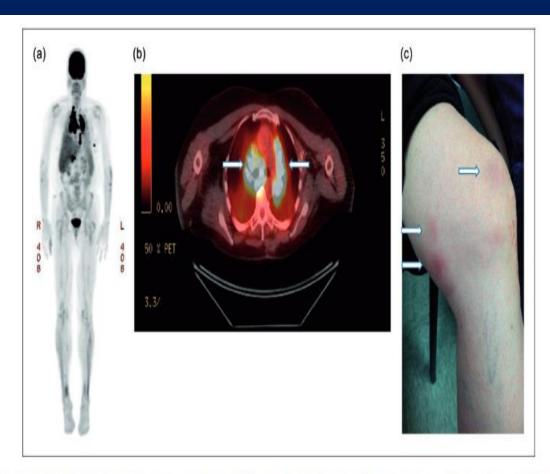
Full body PET CT; (a) Sagittal image shows diffuse mediastinal and hilar lymphadenopathy; (b) Axial fused FDG-PET/CT image shows new FDG-avid mediastinal and hilar lymphadenopathy; (c) erythema nodosum.
